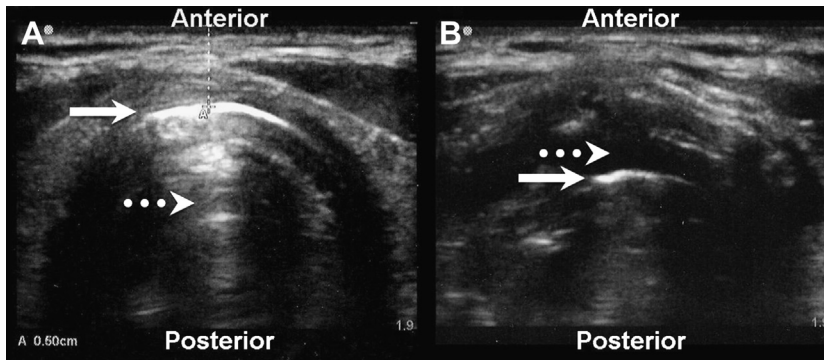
Ultrasonography for PDT. Demonstration of ultrasound images of the neck and trachea. (A) Normal trachea imaged above a tracheal ring. Tracheal cartilage (solid arrow) creates a shadow artifact (dotted arrow). Image depth of 1.9 cm is indicated in the lower right corner. The dotted line measures the distance between the skin and anterior trachea to be 0.50 cm, as indicated in the lower left corner. (B) Intubated trachea imaged between tracheal rings. The ETT (solid arrow) and associated shadow artifact is visualized within the tracheal lumen (dotted arrow).
